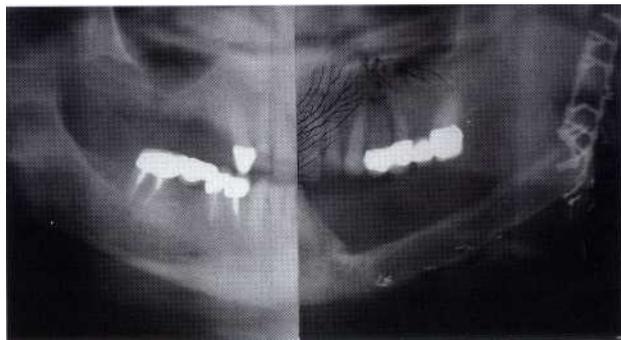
Postoperative Panorex radiograph (12 months later) of a patient with a hemimandibulectomy and reconstruction with microvascular free flap fibula, showing full bony consolidation.
